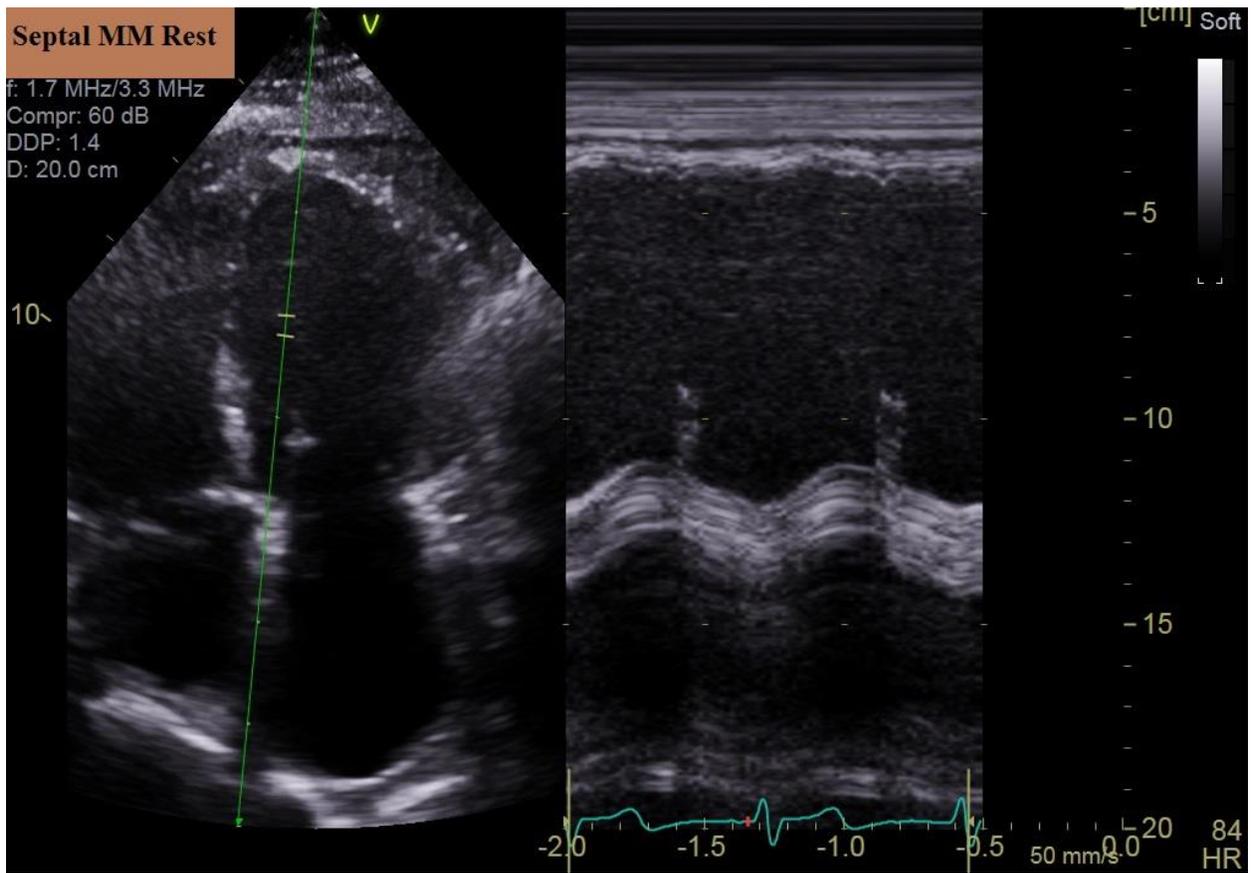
Trans-thoracic echocardiography, Septal M-mode at rest.
